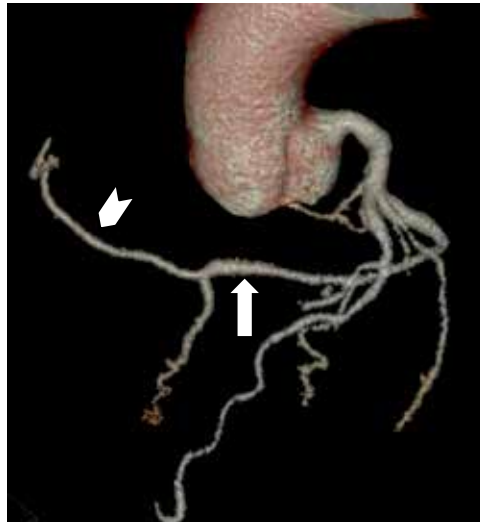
Volume-rendered computed tomography image showing a single coronary artery with a normal left ostium, and a circumflex coronary artery (arrow) supplying the myocardium usually fed by the right coronary artery (arrow head).
